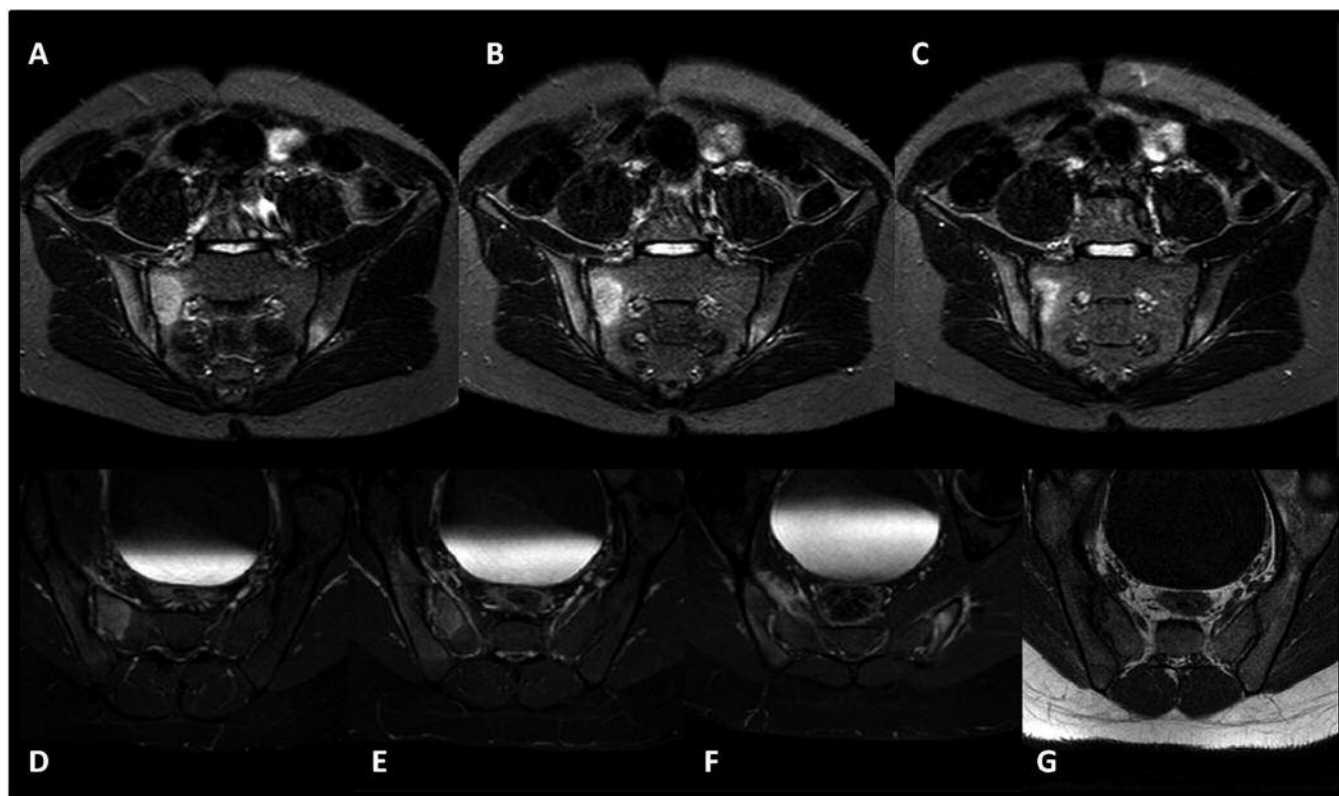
MRI images of a 13-year-old boy with HLA-B27-positive ERA/JIA and inflammatory back pain. A, B, C. Three semicoronal STIR images show bone edema in the sacral cartilaginous portion of the right sacroiliac (SI) joint and in the iliac ligamentous portion of the left joint. D, E, F. Corresponding semiaxial T1 SPIR images after gadolinium injection showing enhancement in the bone marrow and joint space of the sacral cartilaginous portion of the right SI joint and in the bone marrow of the iliac ligamentous portions of the left SI joint. G. Semiaxial T1 spin-echo image showing sclerosis and erosion in the sacral cartilaginous portion of the right SI joint.
